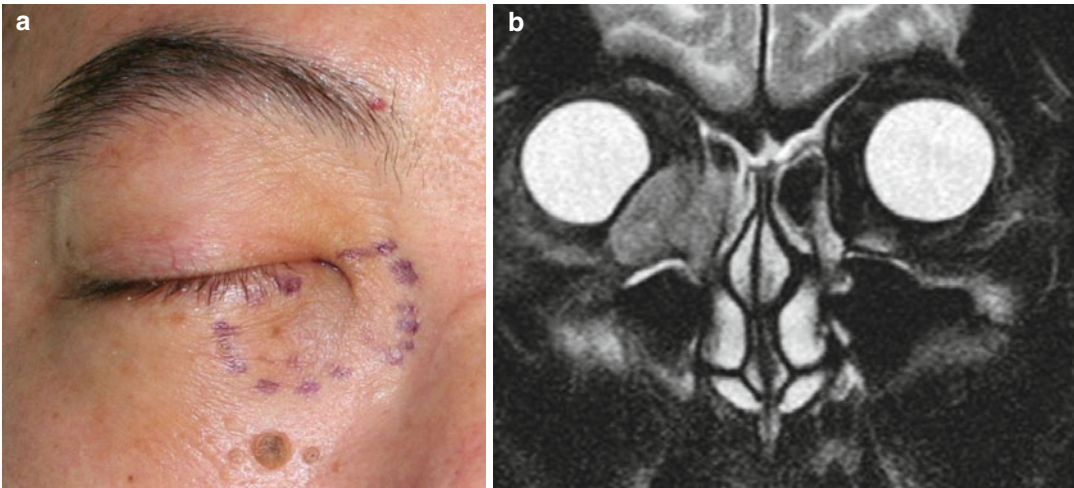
(a) Carcinoma of right lacrimal sac and nasolacrimal duct. (b) MRI showing infiltration of the right lacrimal drainage apparatus with globe displacement
